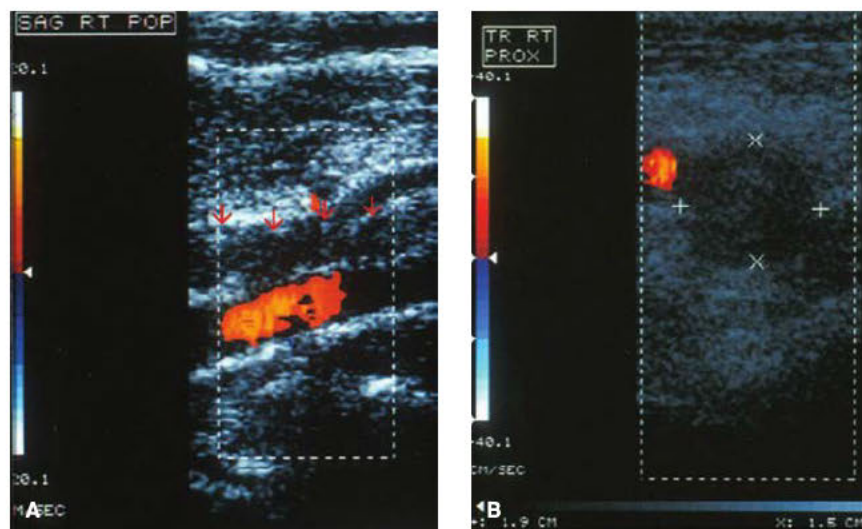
Sagittal (A) and transverse (B) images from a lower extremity. Color Doppler ultrasound study in a woman with popliteal vein thrombosis. A. Red arrows demarcate the popliteal vein with no flow suggesting clot in the lumen, which sits above the artery demonstrating normal flow as evidenced by the red color map. B. The transverse image shows the large size of the vein due to the thrombus (cursors), as well as normal flow in the artery, evidenced by the red color map.
